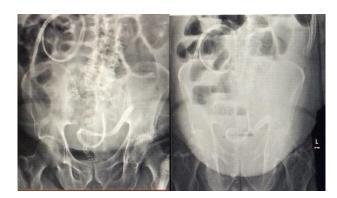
X-ray abdomen, upright views showing distended loops of the small bowel.
